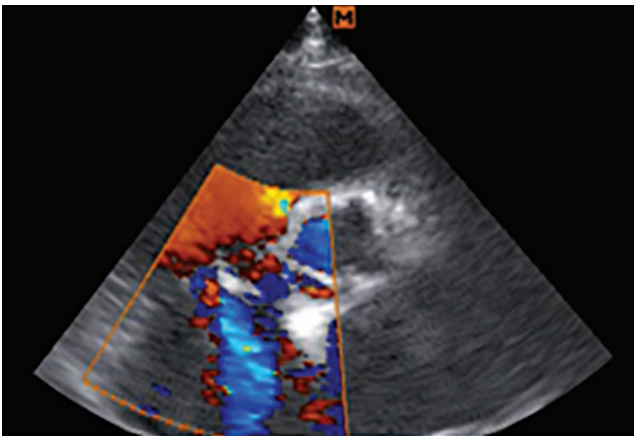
Parasternal short axis view. Color Doppler mapping mode. Tricuspid regurgitation (Blue flow)
